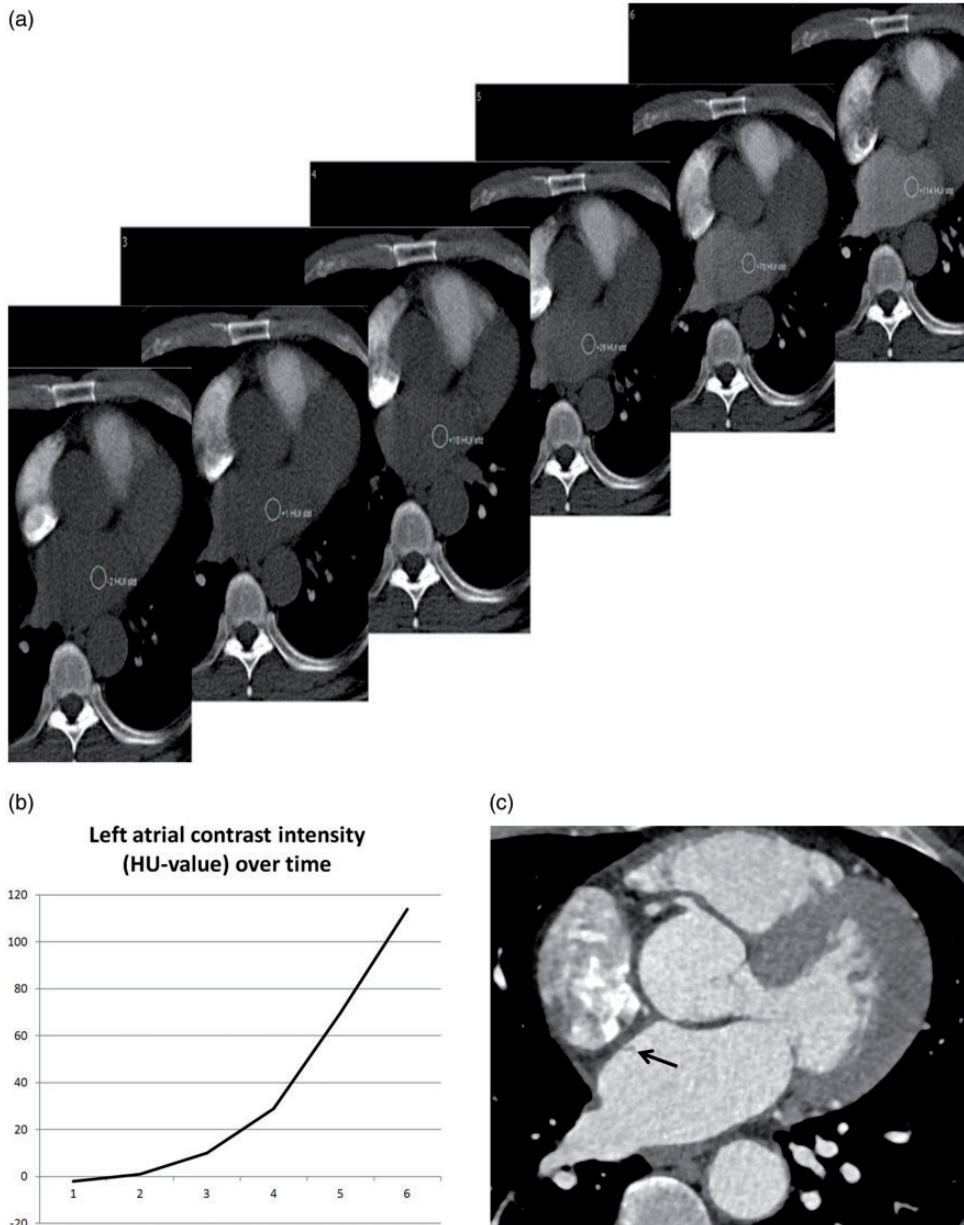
Cardiovascular computed tomography images showing alternative placement of pre-scan contrast intensity measurement region of interest (ROI) in the left atrium and simultaneous measurement of the potential right to left contrast shunt. (a) Bolus track ROI in the left atrium. (b) Left atrial contrast intensity curve. (c) Patent foramen ovale indicated by discrete septum primum prominence into the left atrium. The black arrow shows a discrete flap, but no retrograde contrast shunt.
